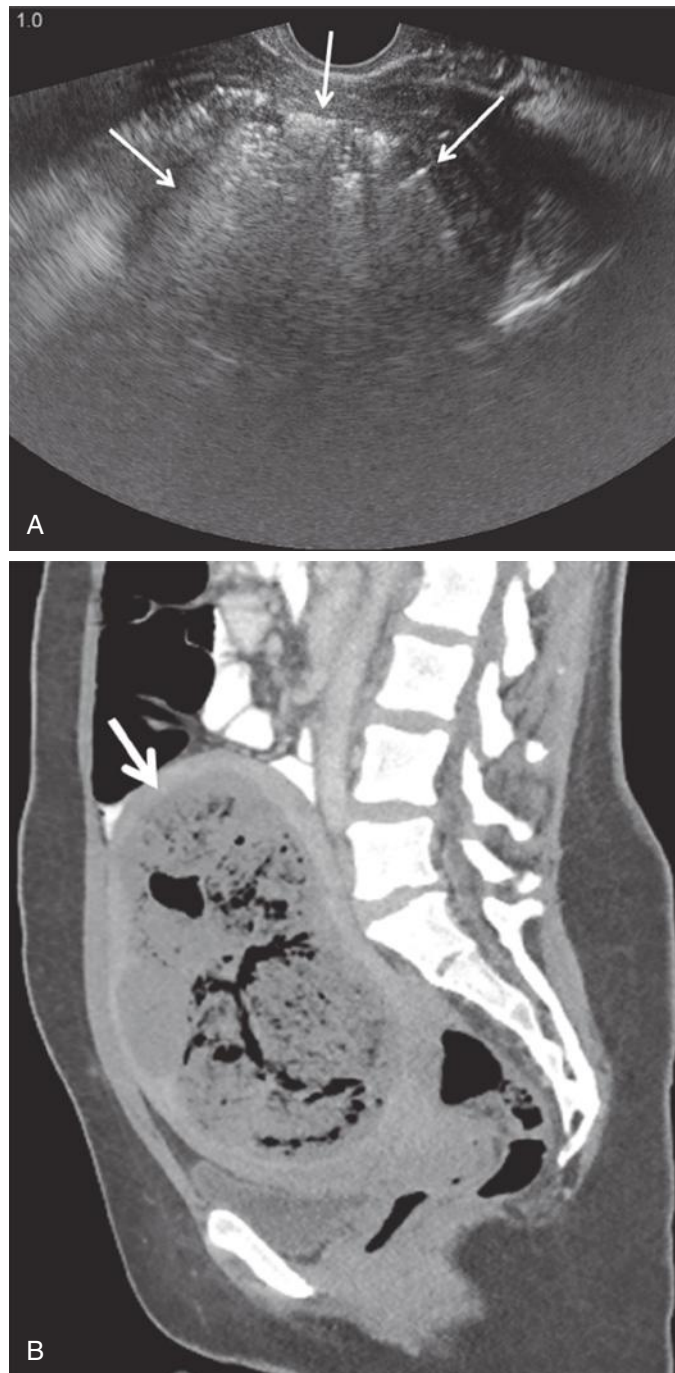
Infected and infarcted leiomyoma (pyomyoma) in patient with fever, vaginal discharge, and pelvic pain 2 weeks following uterine artery embolization. A, Transvaginal sonography demonstrates a large mass in the uterus containing echogenic foci (arrows) with posterior acoustic shadowing and reverberation artifact compatible with gas. B, Sagittal reformatted computed tomography image demonstrates the large leiomyoma (arrow) with extensive infarction and foci of gas. The patient underwent emergent hysterectomy shortly after this scan.
